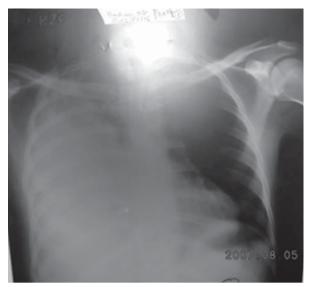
Pre operative X-ray, Chest:
